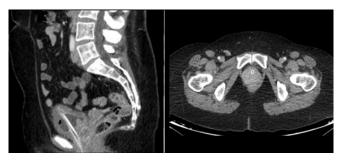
CT scan.A) Sagittal section shows a 7x6cm paraurethral mass with heterogeneous contrast caption that infiltrates the posterior wall of the bladder. Thickened bladder walls and urinary catheter. B) Transverse section of paraurethral mass with urethral catheterization.
